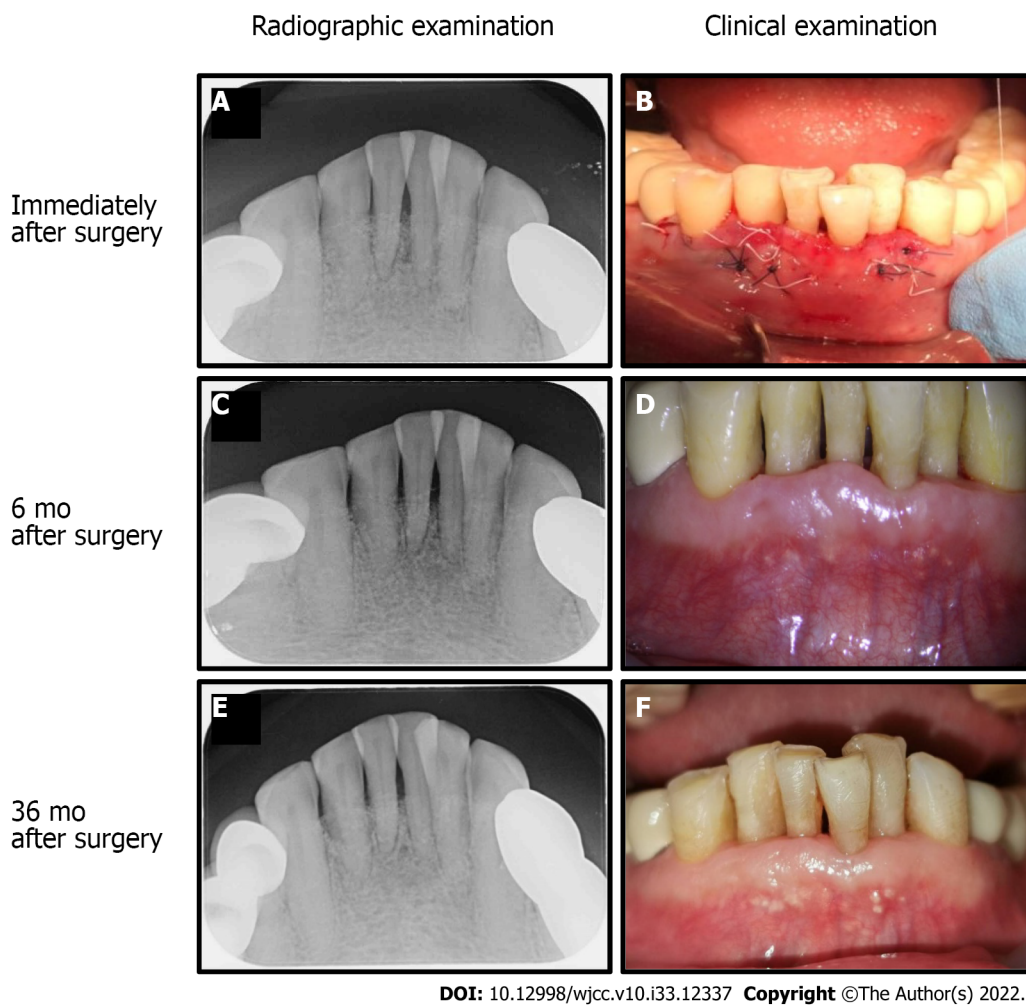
Evaluation of erbium-doped yttrium aluminum garnet laser and advanced platelet-rich fibrin+ treatment in periodontitis. A and B: The radiographic and clinical examinations were taken immediately after treatment; C and D: At 6 mo after combined treatment a reduction in probing depths, gained of clinical attachment level, and radiographic evidence of bone defect fill-in was observed; E and F: Periodontal regeneration was noted at 36 mo.
